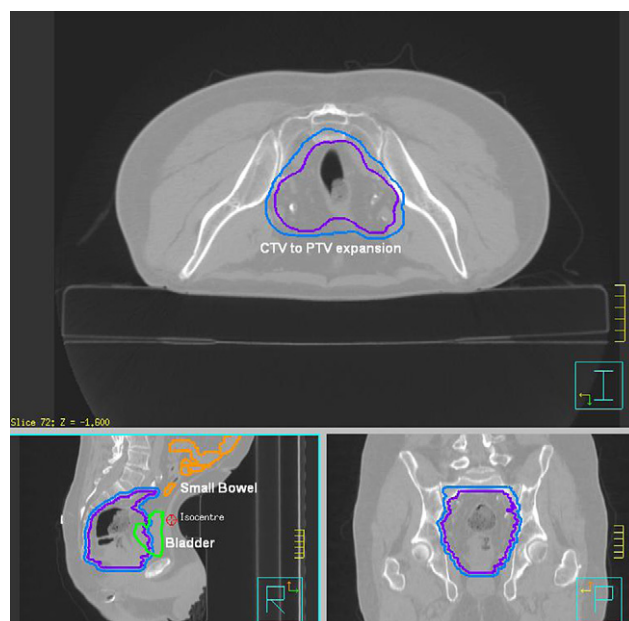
A typical planning CT dataset that includes the clinical target volume (purple), the planning target volume (blue), bladder (green) and small bowel (orange).
